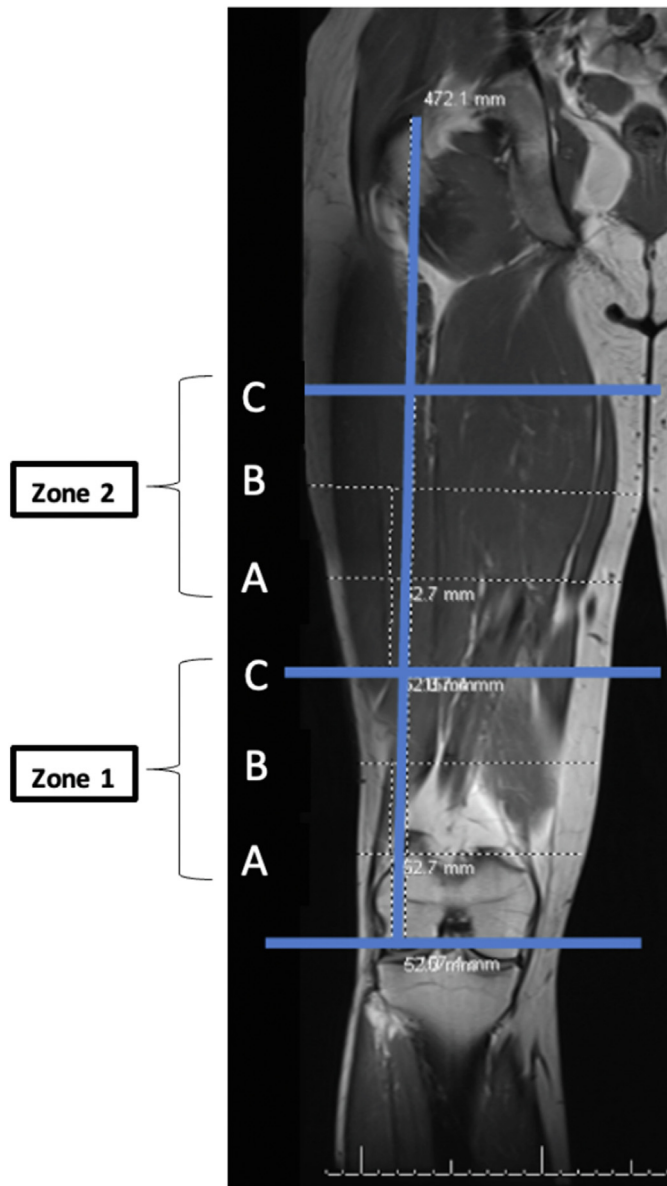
Coronal MRI images of a right femur divided into zones of projected femoral pin insertion sites. MRI, magnetic resonance imaging.
